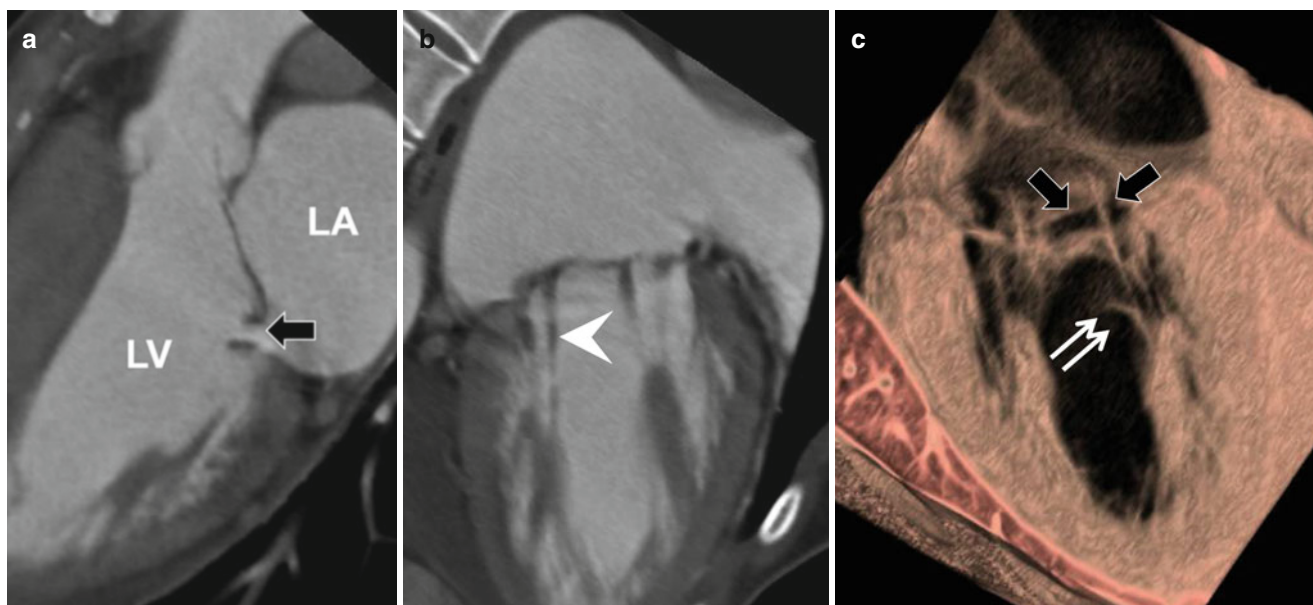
Rheumatic mitral regurgitation due to prolapse of the anterior leaflet. (a) Three-chamber view of CT image demonstrates prolapse of the anterior leaflet and resultant coaptation defect (*arrow*). (b) Oblique view of CT image shows thickening of chordae tendineae
